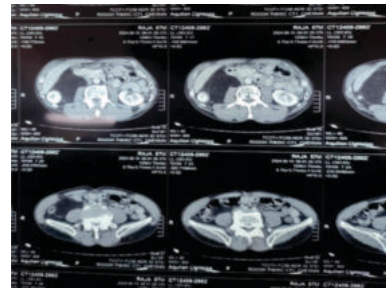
CT Image Showing Right Pararenal Retroperitoneal Lipoma
